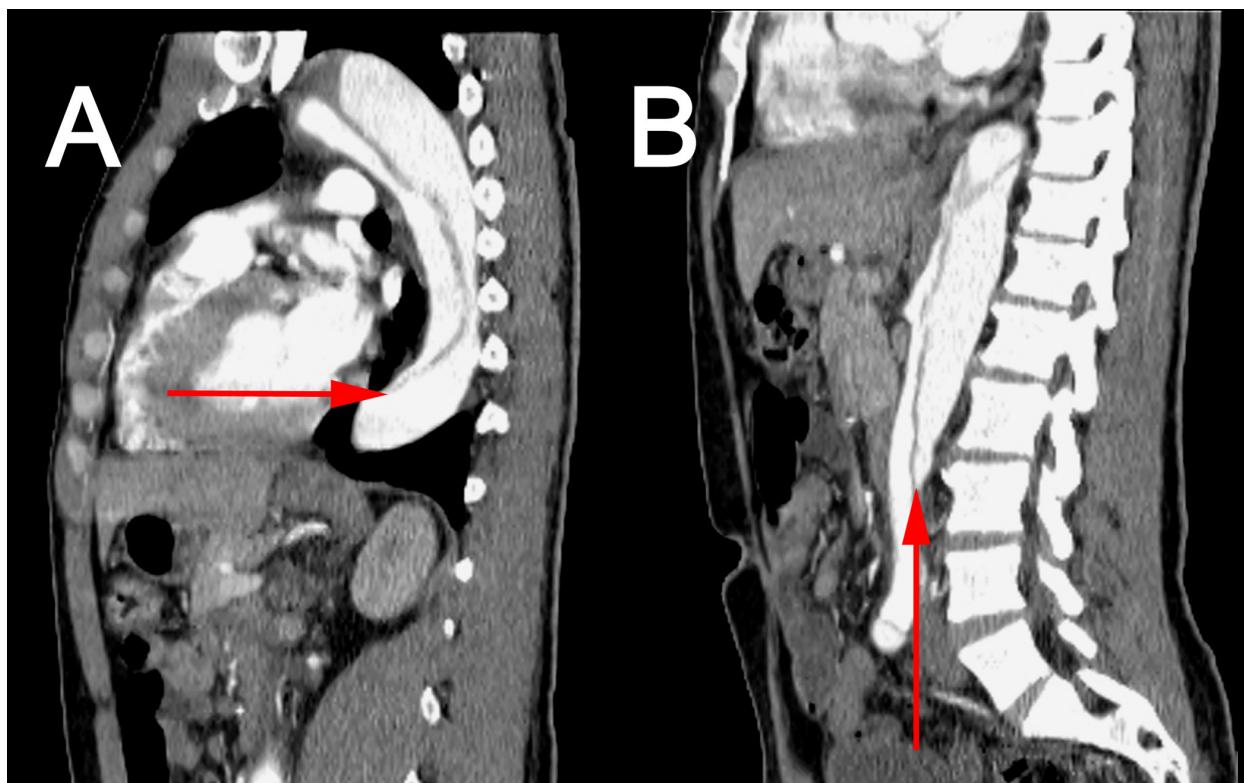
Sagittal computed tomography images demonstrating the thoracic (A) and abdominal (B) portions of the involved dissecting aorta with arrows indicating the dissecting intimal flap.
